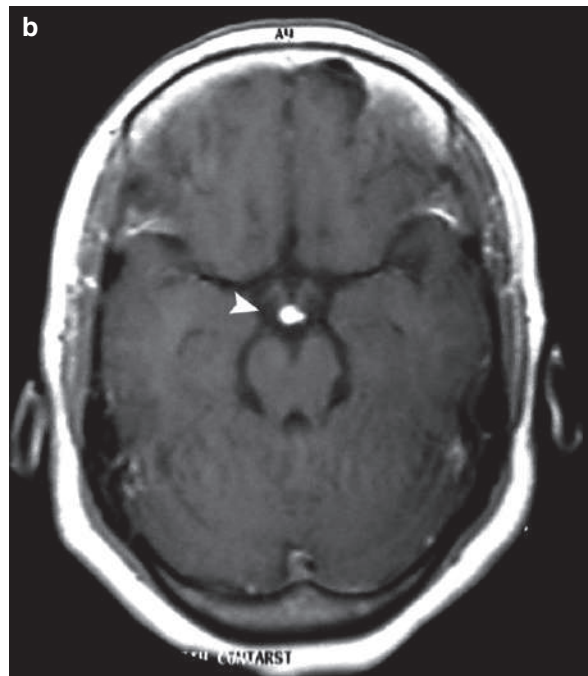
Sagittal (a) and axial (b) T1W MRI shows an ectopic high signal intensity spot located at the proximal part of the infundibulum (ectopic posterior pituitary)
